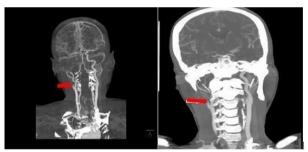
Right internal carotid artery occlusion on CT neck angiography
